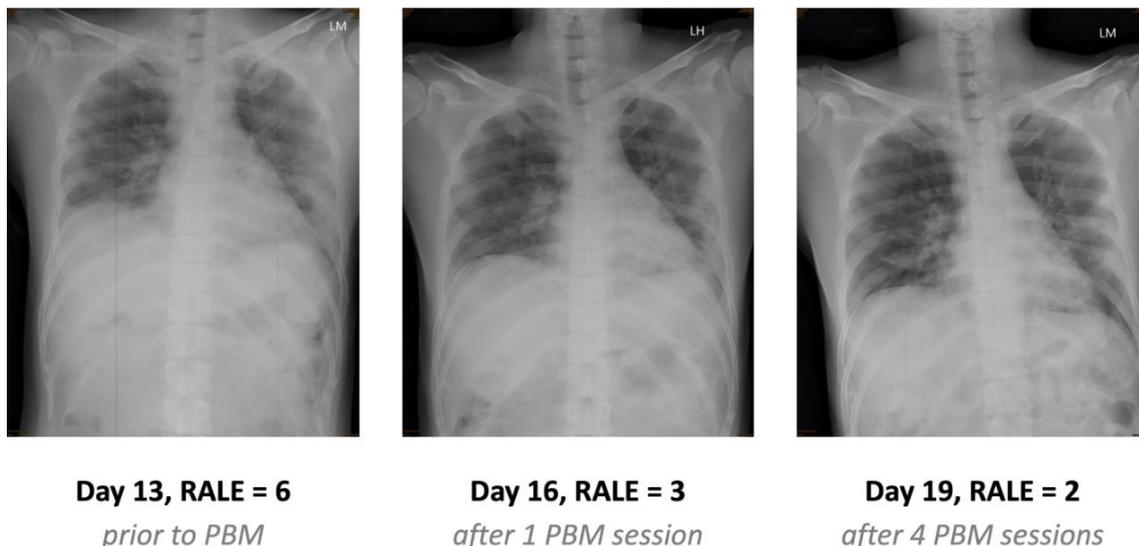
Improvement of X-ray pulmonary optical transmissibility as a result of photobiomodulation sessions. Immediate improvement is discernable after 1 PBM session with significant change after four.
